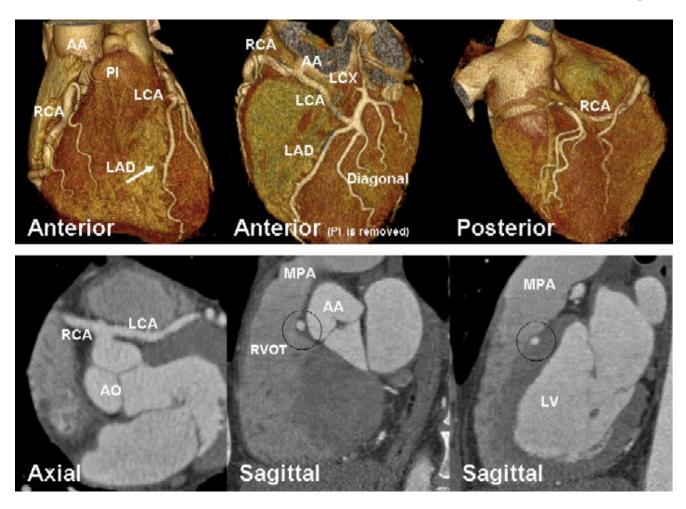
Case#1(anterior variant), CT coronary angiography demonstrates a single coronary artery arising from the right coronary cusp bifurcating into the RCA and LCA. The RCA is the dominant artery. The left circumflex artery is continuation of the LCA in the atrioventricular groove and the LAD is a branch of the LCA. Three dimensional volume rendered and axial images are shown in upper row and maximum intensity angiographic projections in lower row.
